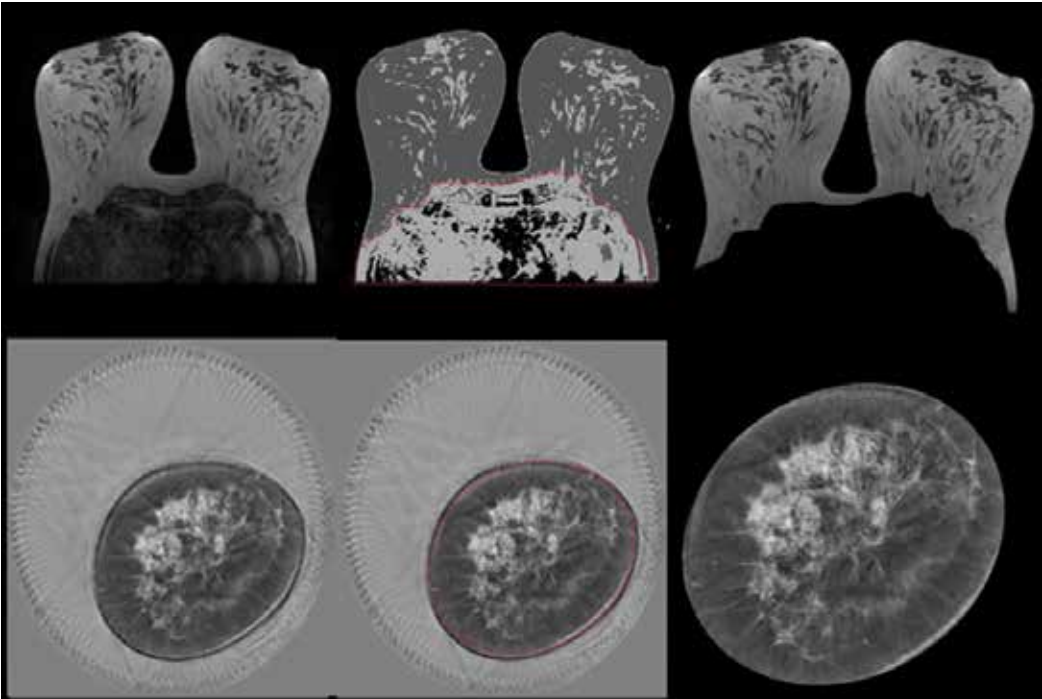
The segmentation process for MR images (top) and UST images (bottom). From left to right, original image, segmentation boundary and the final segmented image.
